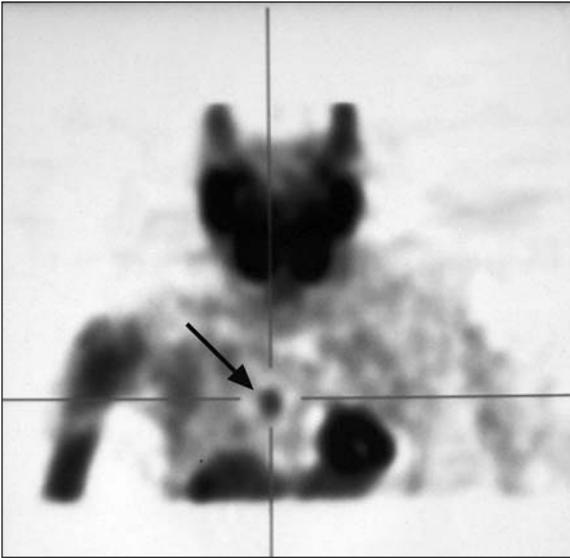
Technetium sestamibi scintigraphy showing a nodule (arrow) in the mediastinum with focal activity.
